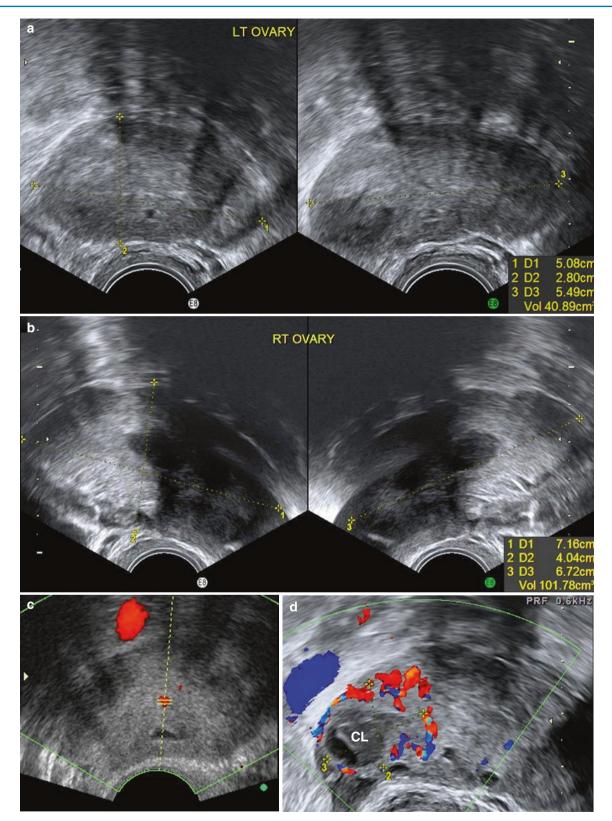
Gorlin syndrome in a 29-year-old patient who came for an early pregnancy scan. Patient gave a history of ovarian biopsy elsewhere which she reported orally to have revealed fibrotic tissue. A very small intrauterine sac was seen. (a) The left ovary was bulky and showed stripy shadows with a few follicles within. (b) Solid, complex, enlarged right ovary showing significant acoustic shadowing. Though both the ovaries appeared fibrotic, with acoustic shadowing, no well-defined fibroma could be delineated within. A few small, scattered follicles were seen. (c) Minimal flow is seen in the ovary on Doppler. (d) A corpus luteum (CL) was seen in the left ovary
